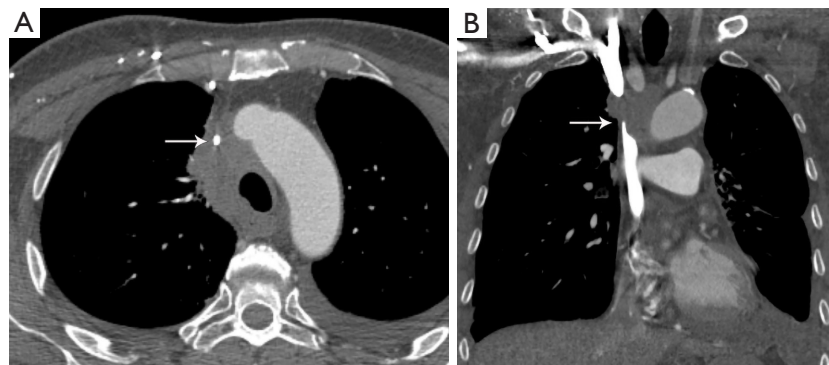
SVC obstruction. (A) Axial contrast enhanced CT shows mediastinal adenopathy due to lung cancer narrowing the SVC (arrow) with multiple collaterals in the right anterior chest wall. (B) Coronal contrast enhanced CT shows the SVC is patent below the level of obstruction due to the adenopathy (arrow). SVC, superior vena cava; CT, computed tomography.
